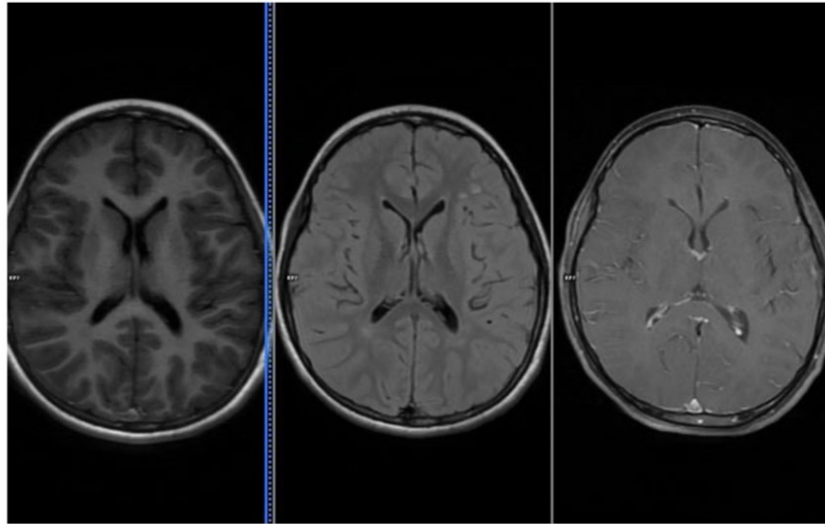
Magnetic Resonance Imaging (MRI) of the brain revealed nonspecific frontal white matter hyperintensities on fluid attenuation inversion recovery (FLAIR) sequence, with no significant abnormality on T1 and T1 post-contrast imaging.
